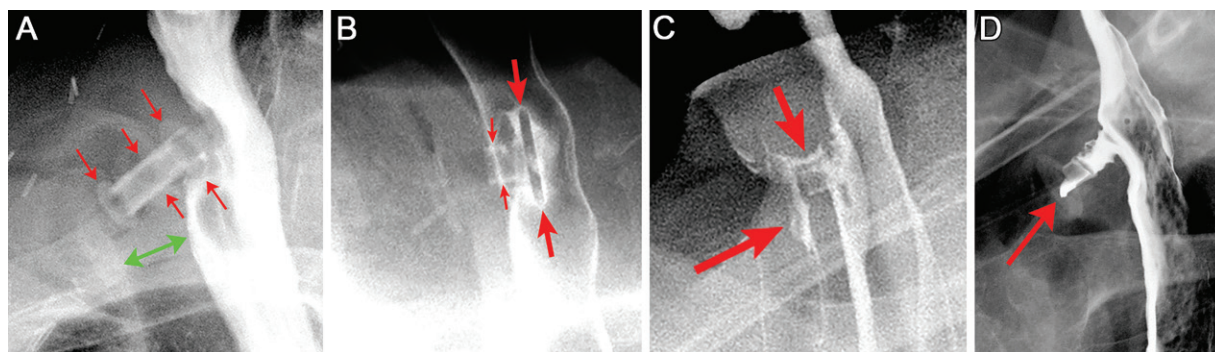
Complications of a tracheoesophageal prosthesis in four patients. (A) Oblique radiograph of swallowing in an 81-year-old woman shows migration of the prosthesis (red arrows) into the lumen of the tracheostoma (green double-headed arrow). (B) Oblique radiograph in a 74-year-old man after swallowing shows the esophageal flange of the prosthesis (arrows), which is malpositioned in the lumen of the proximal esophagus instead of being attached to the wall. (C) Oblique radiograph in a 79-year-old patient after swallowing shows contrast material leaking from the esophagus into the tracheal lumen through the surrounding cephalad margin of the prosthesis (arrows). (D) Oblique radiograph in a 72-year-old man shows contrast material dripping into the trachea through the lumen of prosthesis (arrow).
